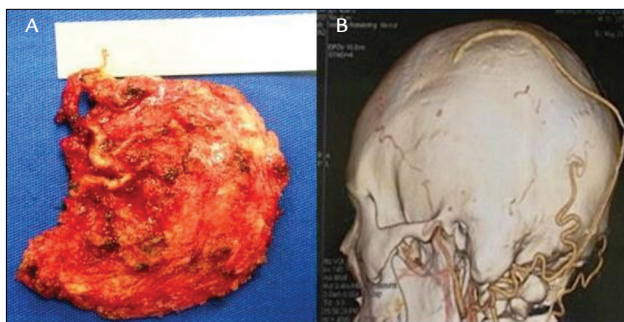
A. The scalp AVM shown after *en bloc* resection. B. Postoperative CT showing no significant and/or pathologic vessels relative to the AVM.
